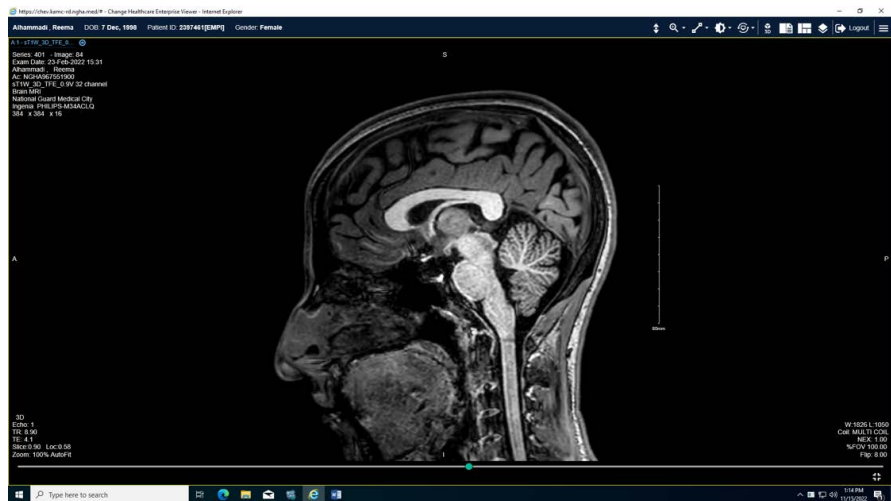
MRI scan showing the cysts at the nasal septum.
